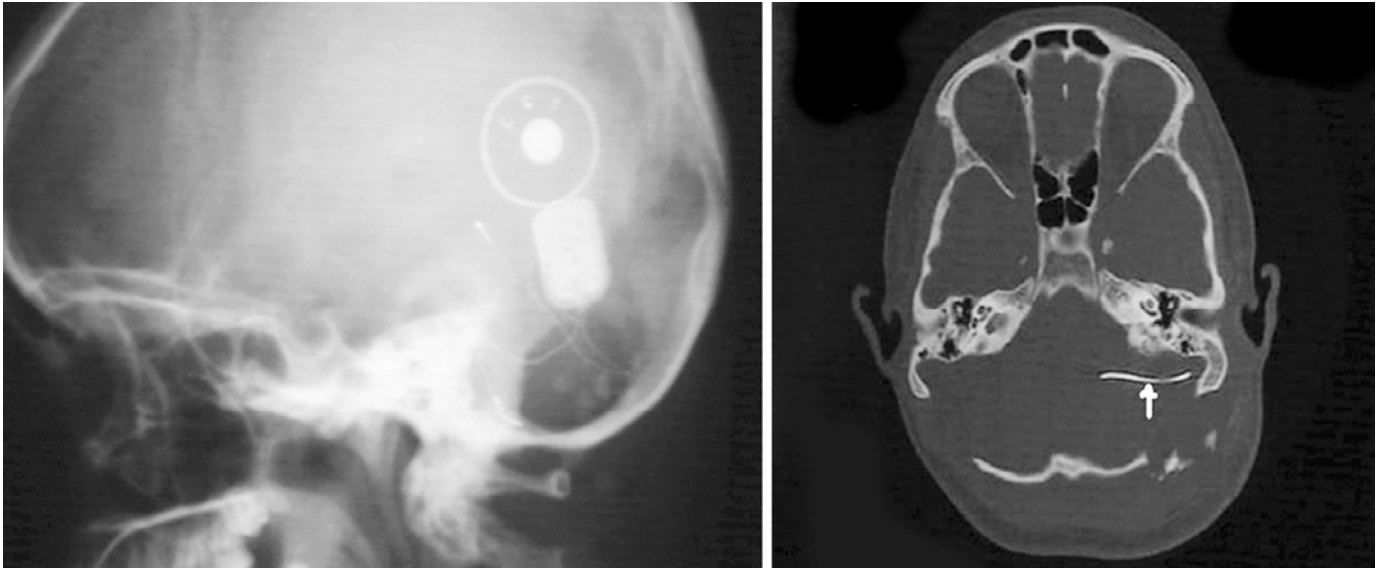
Post-operative X-ray and CT scan showing auditory brainstem implant
